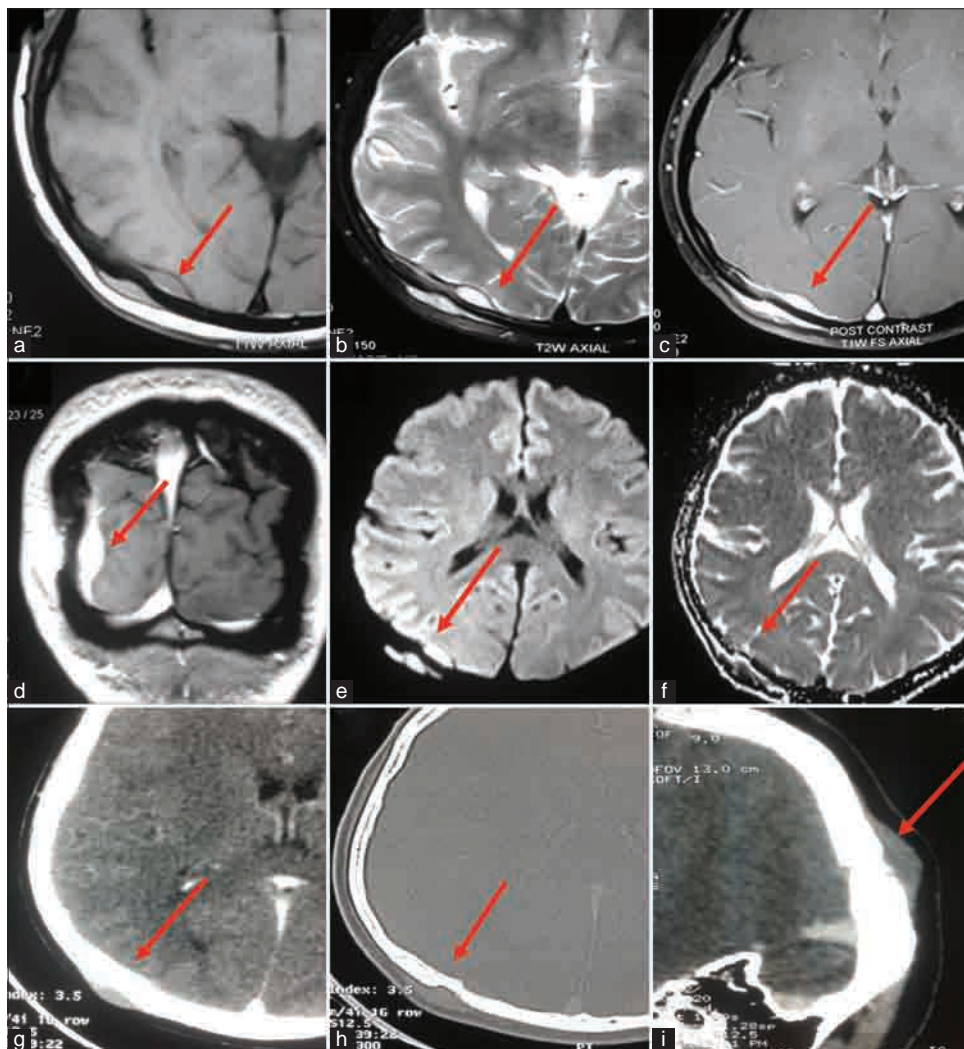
MALT dural lymphoma. (a) T1w-weighed imaging showing an extra-axial isointense lesion on both sides of diploic bone. (b) T2w images showing a hyperintense lesion with CSF cleft. (c and d) Post-contrast T1w images showing homogenous contrast enhancement with wide dural base. (e and f) Diffusion-weighted Imaging and ADC images showing diffusion restriction with corresponding black signal on the ADC. (g-i) CT brain plain showing bone calvaria with minimal sclerosis
